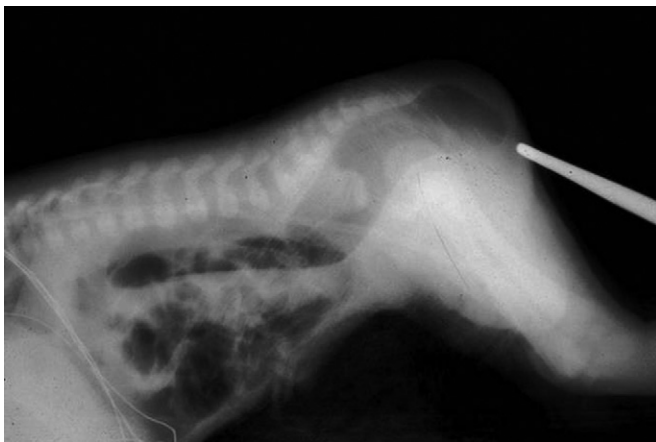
Cross-table lateral radiograph, reachable rectum.
